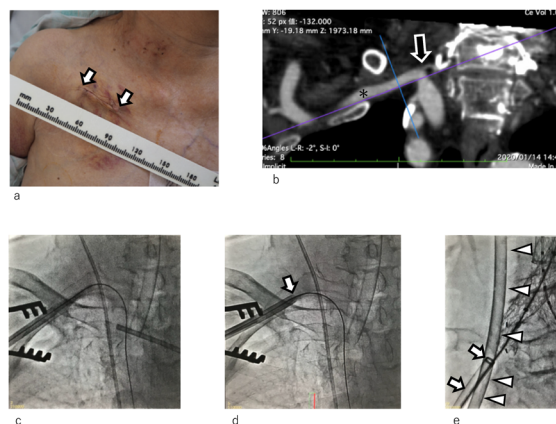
Images during the surgery: (a) An image of the wound for the right axillary artery exposure and cannulation (arrows). (b) Preoperative computed tomography (CT) images of the right axillary and subclavian artery. An asterisk (*) denotes the planned cannulation site, and an arrow denotes the vertebral artery. (c) Fluoroscopy image during insertion of the inflow cannula. The cannula was inserted using the direct Seldinger method. (d) Fluoroscopy image after placement of the inflow cannula. (e) Fluoroscopy image during endovascular stent-graft placement. Arrow heads: 21 Fr outflow cannula, arrows: 16 Fr guiding sheath for stent-graft placement.
